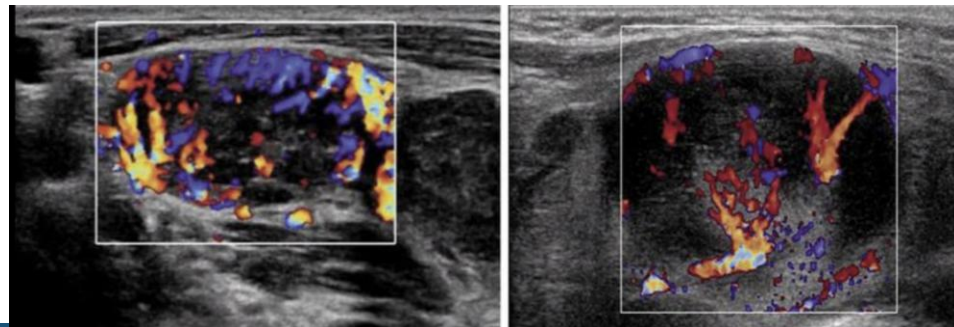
Colour Doppler reveal Well-Defined Oval Shape Lymph Node showing Central Type of Vascular Pattern in Benign Case (Figure A), while Peripheral Vascular Pattern in Malignant Lymph Node (Figure B)
